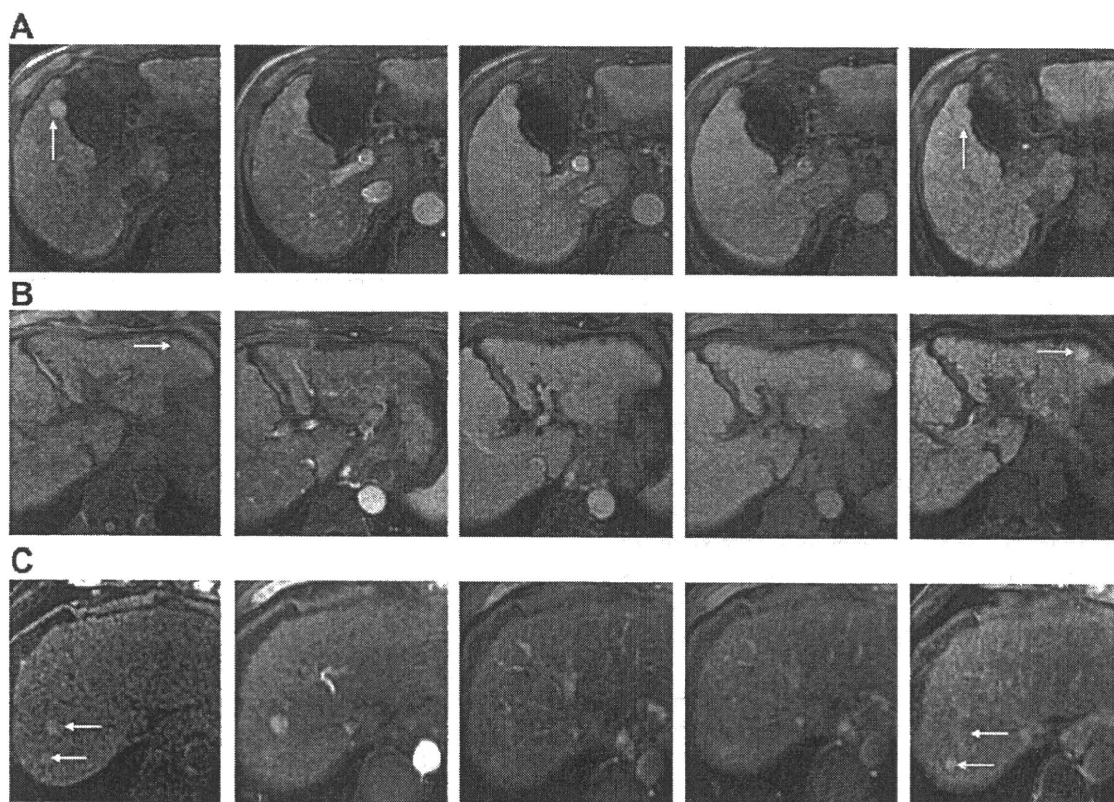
Dynamic enhancement patterns of a low-grade dysplastic nodule (A), high-grade dysplastic nodule (B), and well-differentiated HCCs (C) in axial T1-weighted fat-saturated 3D GRE images (TR/TE = 3.6/1.7 ms, flip angle = 15°), presenting before and in the arterial phase, portal phase, equilibrium phase, and hepatocyte-selective phase after intravenous injection of Gd-EOB-DTPA. In the hepatocyte-selective phase, each nodule is observed as isointense or hyperintense owing to the uptake of hepatocellular agents (arrows). In series (C), both nodules were well-differentiated HCCs. In the hepatocyte-selective phase, both HCCs are observed as isointense and hyperintense, respectively. All these HCCs were diagnosed by needle biopsy.
